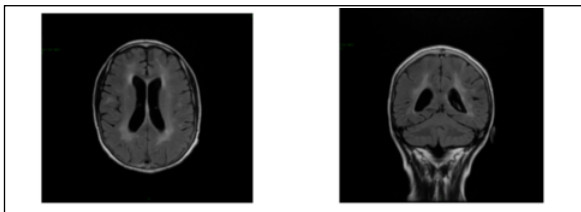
A: Axial and coronal FLAIR MRI (November 2012).
